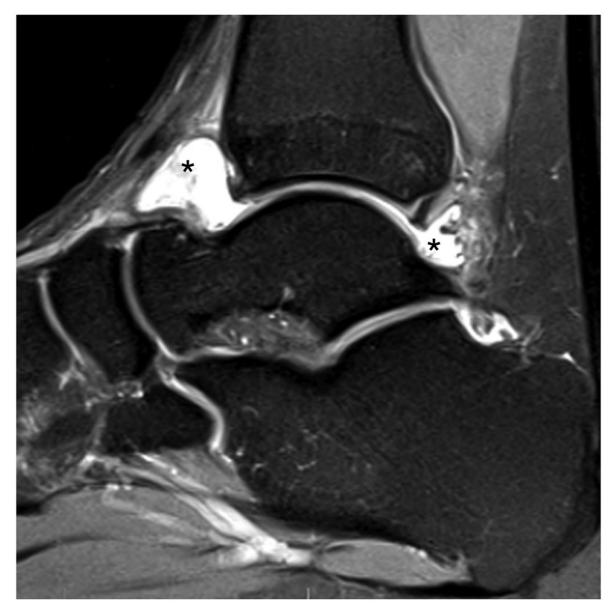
Traumatic joint effusion. Sagittal proton density–weighted fat-saturated magnetic resonance imaging shows a large amount of joint effusion anteriorly and posteriorly at the tibiotalar joint (asterisks).
